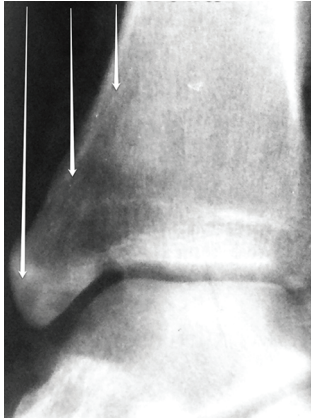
X-ray of the medial ankle 2 weeks after osteosynthesis with a bioabsorbable screw
